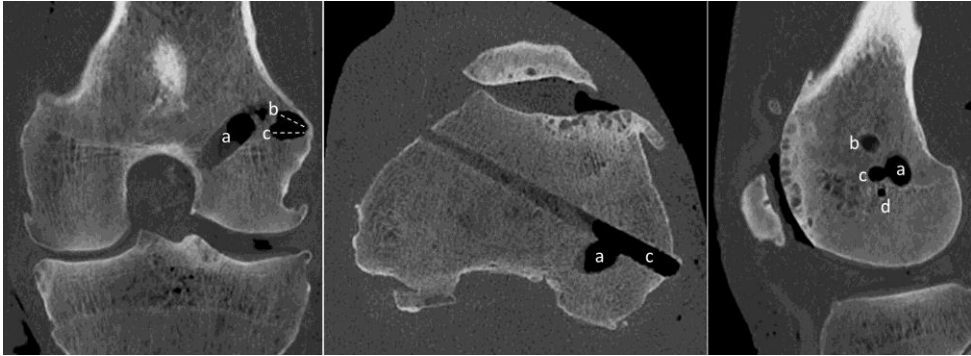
Computed tomography scan of tunnel convergence in the coronal, axial and sagittal plane. a = ACL tunnel; b= 30° coronal and 30° axial ALL tunnel; c= 0° coronal and 20° axial ALL tunnel; d = transepicondylar axis
